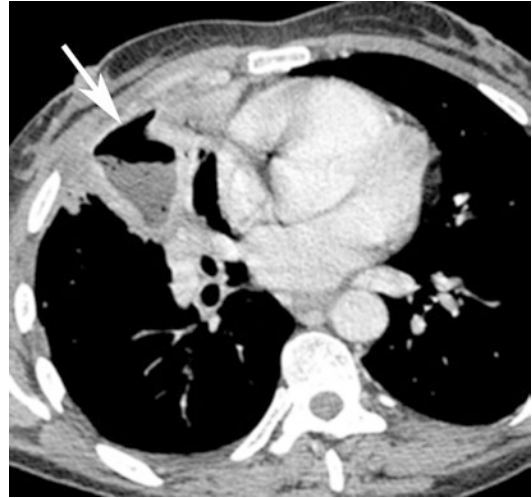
Post-contrast axial CT scan shows a middle lobe atelectasis associated with an abscess (*white arrow*)
